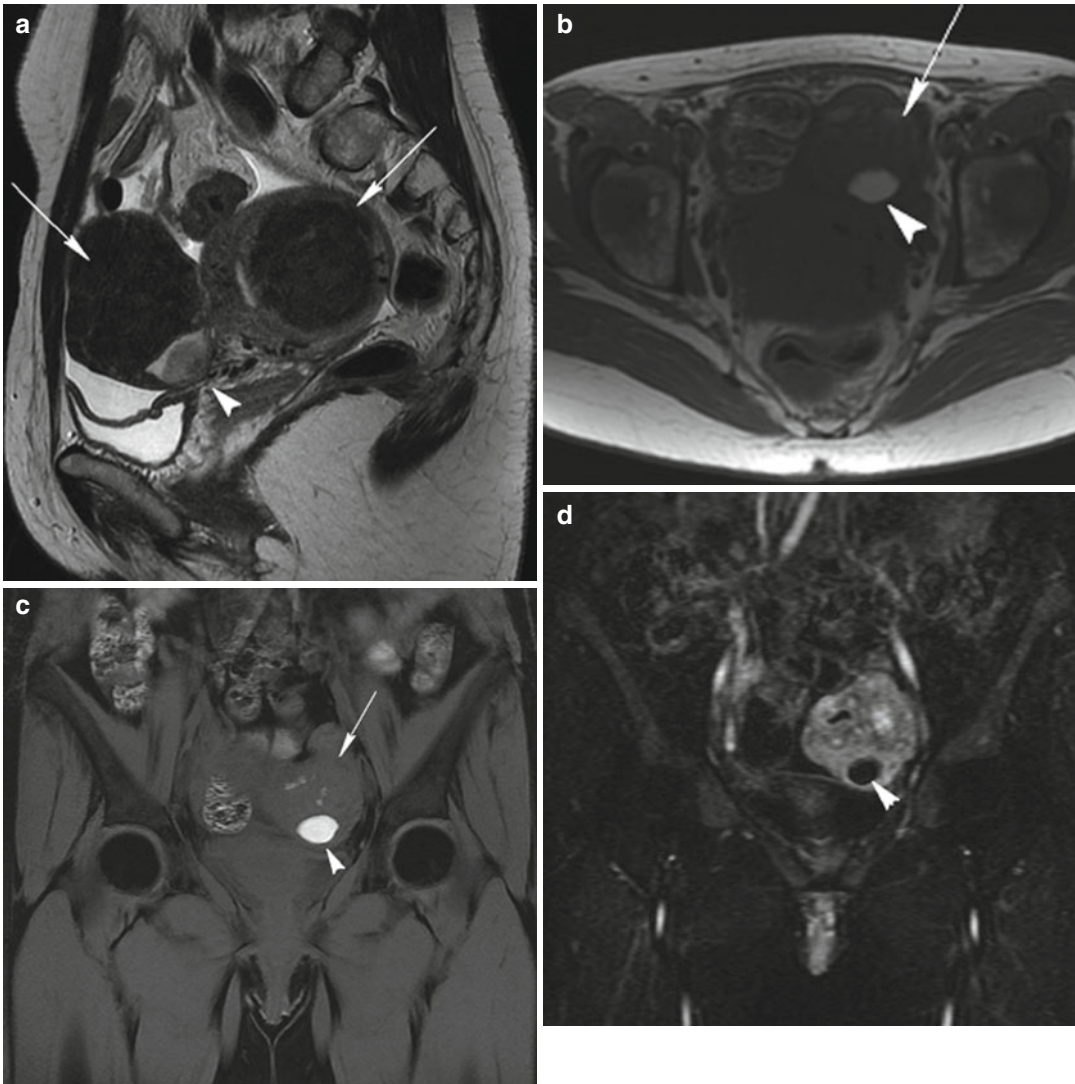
Fibroid with red degeneration. Sagittal T2-weighted image (TR 4,500 ms, TE 90 ms) (a) shows two hypointense well-defined uterine masses (*arrows* in a, b and c), one is an intramural non-degenerated fibroid, and the other is a subserosal pedunculated fibroid with a well-defined hyperintense area, which has some content with intermediate signal intensity (*arrowhead* in all images) that is a degenerated focus. This degenerated area has very high signal intensity on axial T1-weighted (TR 600 ms, TE 10 ms) (b), and coronal fat-suppressed
